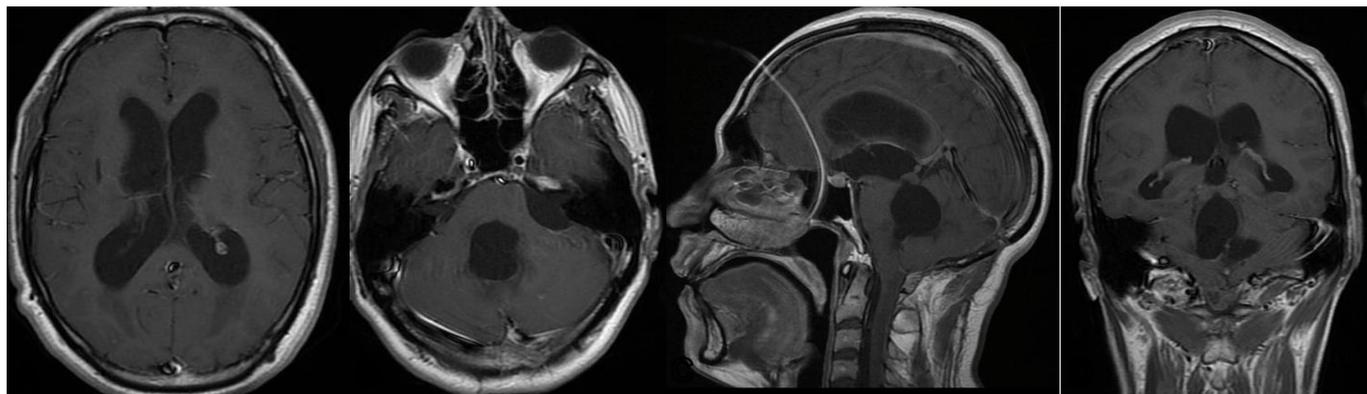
(A and B) MRI of the brain with contrast on admission, in axial section at the level of lateral ventricles and the IV ventricle. (C and D) Brain MRI with contrast in sagittal and coronal section showing severe dilatation of the IV ventricle without evidence of cysticercus cysts.
